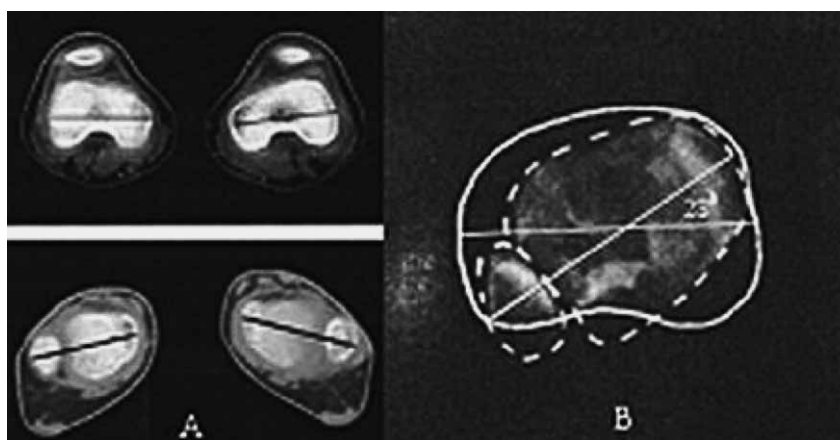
Computed tomography method for measuring tibial torsion. The ends of the transcondylar (femoral) and transmalleolar axis represent the placement of the epicondylar (femoral) and malleolar cups of the torsiometer. The epicondylar position of the femoral cups is interpreted to represent the transcondylar axis of the tibia (A). On the superimposed tibial and malleolar scans, the angle described by the goniometric scale reflects the angle formed by the transmalleolar axis with the transcondylar axis of the tibia (B).
